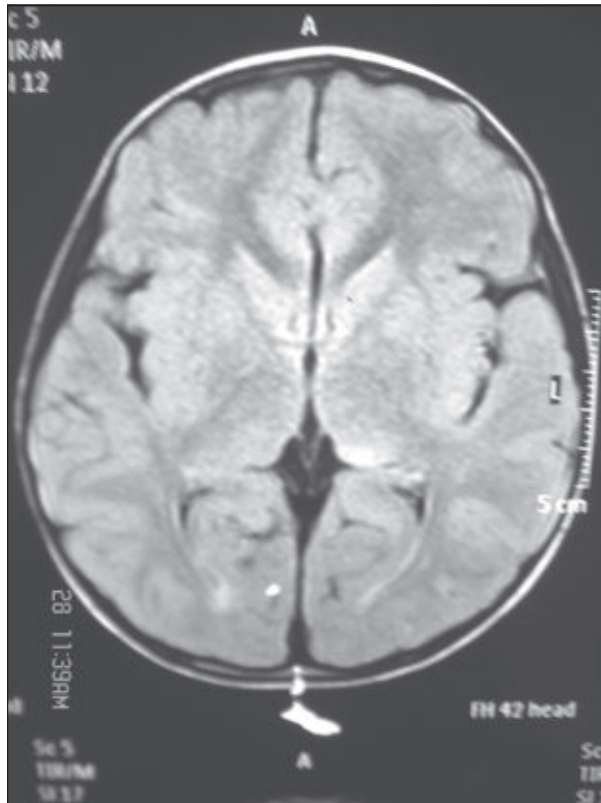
Normal MRI of brain of the first case
